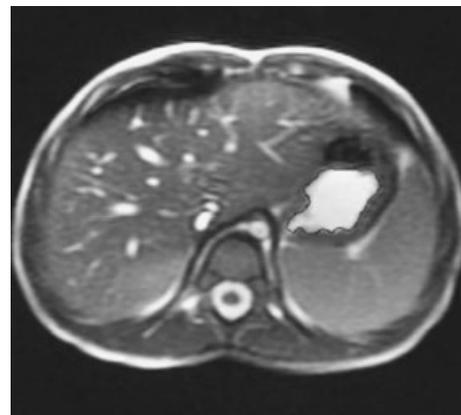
Manually traced liquid content on axial MRI slice.
